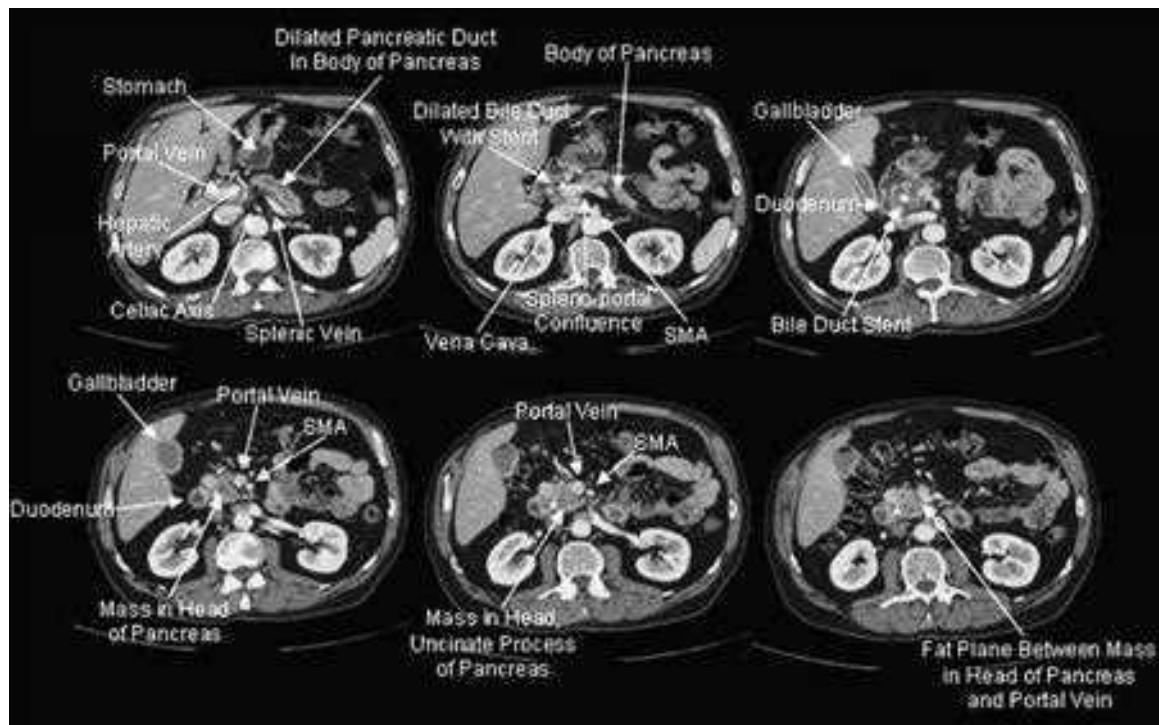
Computed tomography scan demonstrating resectable pancreatic cancer. SMA = superior mesenteric artery.
